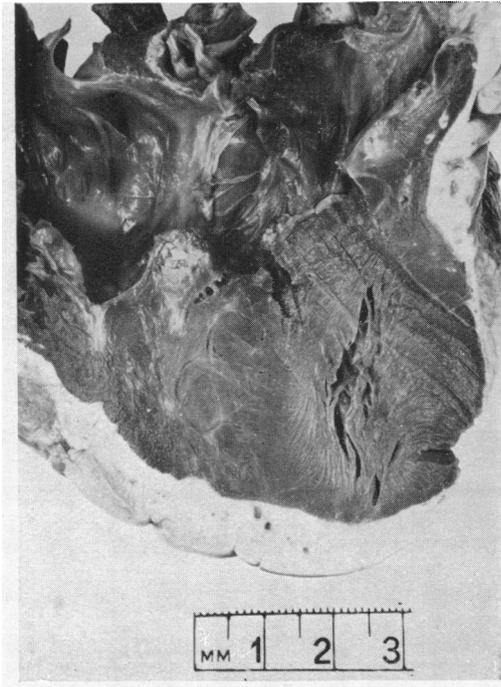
Section through the apex of the right ventricle, showing extreme obliteration of the inflow tract, deposits of calcium below the endocardium, which is only moderately thickened, and the massive wedge of muscle which has resulted from apposition of the walls of the right ventricle. The section has just gone into the left ventricle, the cavity of which is seen on the right of the picture. Thick layer of epicardial fat (Case 1). See Fig. 18 for X-ray of this heart.
